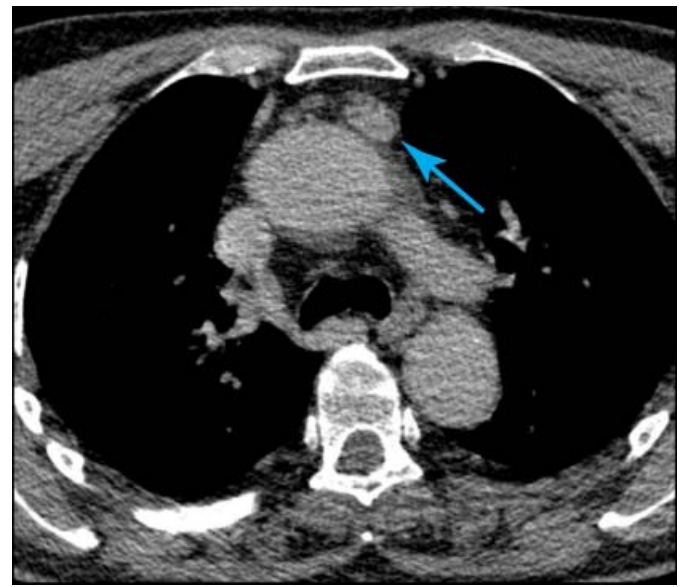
4D CT scan of an adenoma which required a thoracoscopic reoperation
